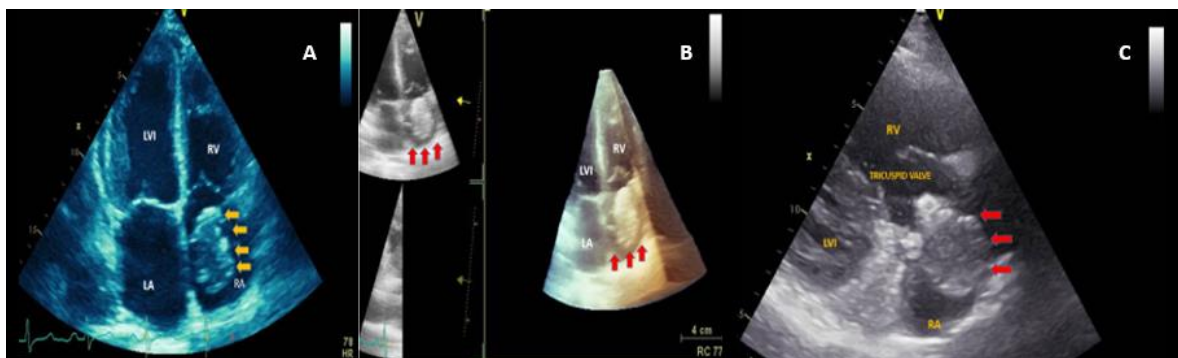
Thoracic Echocardiogram
